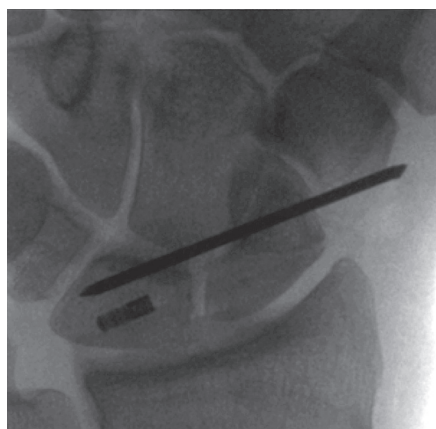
Plain radiograph (A/P view) of the SL axis method (SLAM), with a centrally fixed tendon graft in the lunate.
